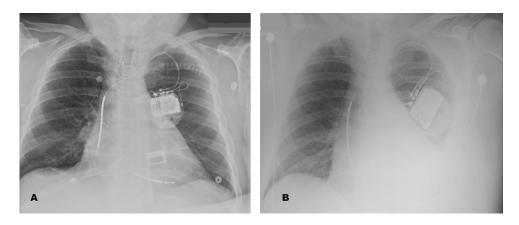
A, Radiograph showed development of a moderate-sized left pleural effusion, postprocedural chest radiograph showed no evidence of pneumothorax, pericardial or pleural effusion with the lead tip in the right ventricle; B, radiograph showed development of a moderate-sized left pleural effusion position with no clear evidence of right ventricular perforation.
